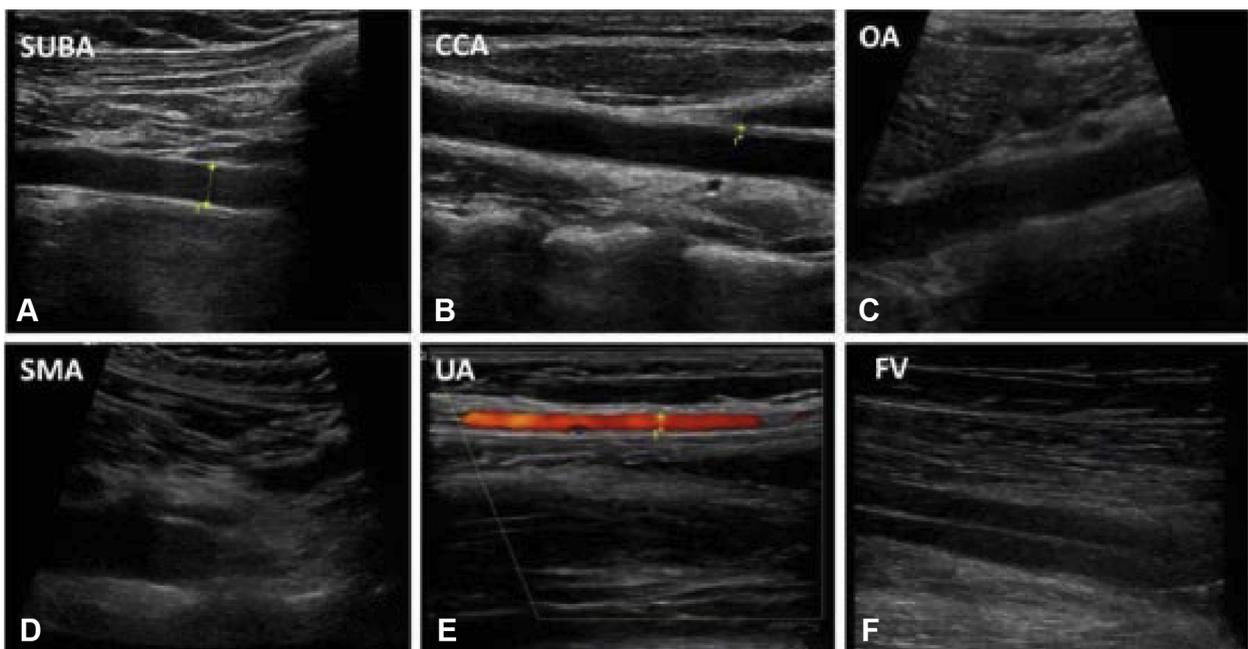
Ultrasound examination images after glucocorticoid impulse therapy for 4 months. The wall thickening of the involved vasculature was alleviated. A, The wall thickness of the subclavian artery (*SUBA*) was 0.8 mm. B, The wall thickness of the common carotid artery (*CCA*) was 0.9 mm. C, The thickening of the upper segment abdominal aorta (*OA*) was 1.0 mm. D, The wall thickness of the superior mesenteric artery (*SMA*) was 0.9 mm. E, The wall thickness of the ulnar artery (*UA*) was 0.7 mm. F, Thickening of the wall of the deep veins in the lower limbs. The wall thickness of the femoral vein (*FV*) was 0.5 mm.
